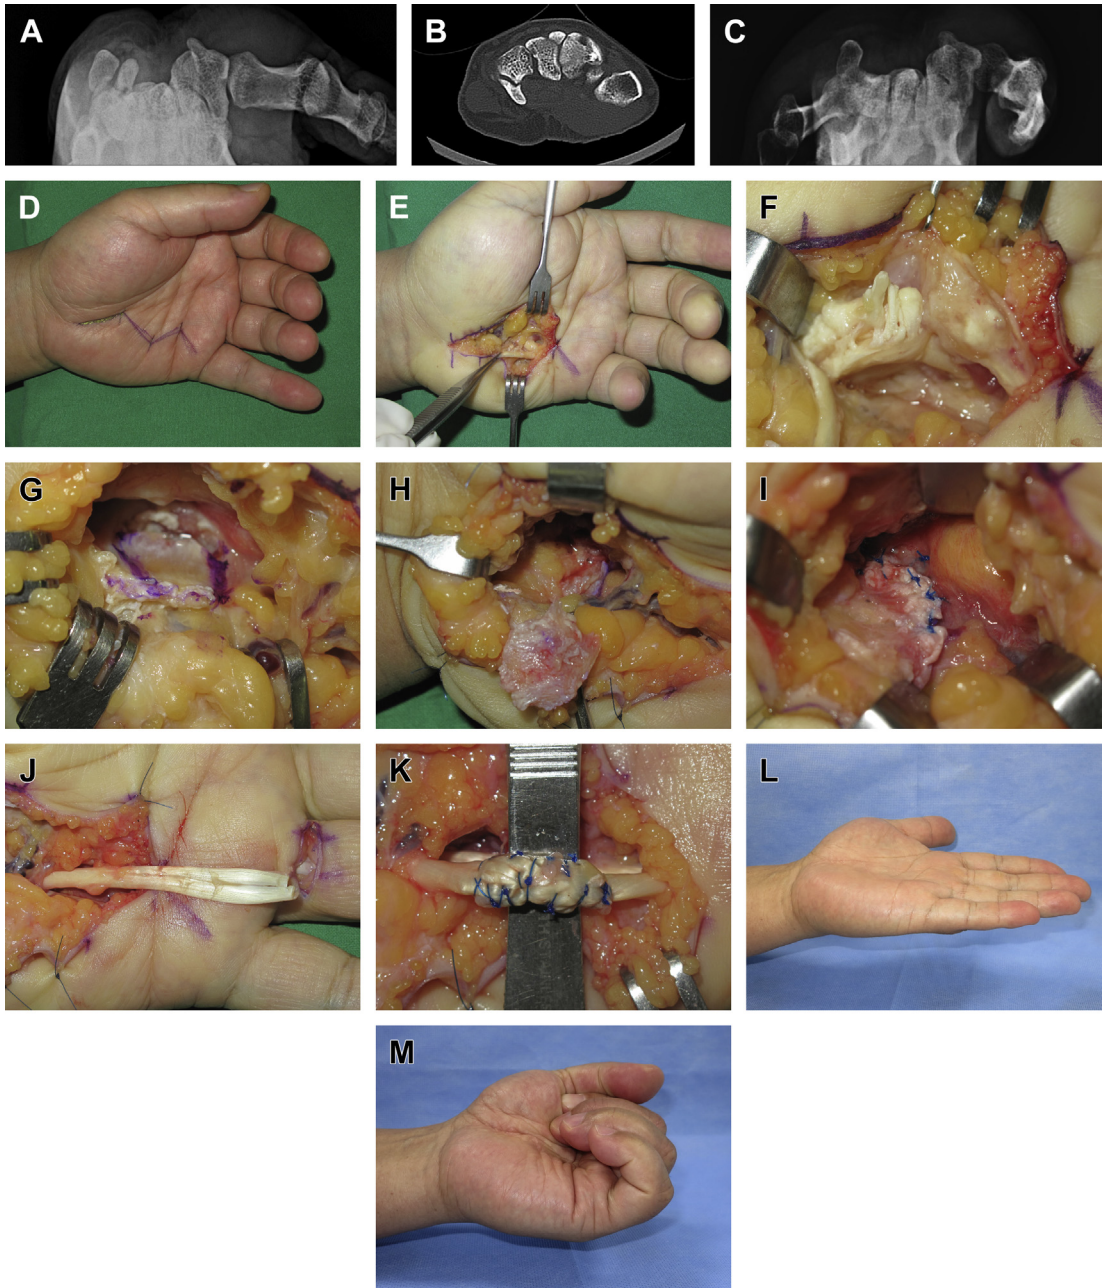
Beginner golfer: a 56-year-old male patient had chronic pain on the left palm and limitation of flexion on the ring and small fingers after intensive golf practice for 3 months. (A, B) On the radiograph of the carpal tunnel view and computed tomography, the base portion of the hook of hamate was fractured. (C) Postoperative carpal tunnel view after resection of the fracture segment. (D) The preoperative view showed destroyed cascade of the ring and small finger and preoperative design for resection of the fractured segment of the hook of hamate, and fourth flexor digitorum superficialis (FDS) tendon transfer for the reconstruction of the fifth flexor digitorum profundus (FDP) together. (E) Complete ruptured fifth FDP at zone III. (F) The fourth FDP was also longitudinally torn. (G) Fractured hook of hamate was identified and periosteal flap based from the ulnar wall of carpal tunnel was designed with gentian violet. (H, I) The fracture segment was excised and then the raw surface was resurfaced with periosteal flap. (J, K) The fourth FDS was harvested from the small transverse incision on the metacarpophalangeal volar crease. Pulvertaft interweaving suture was performed between the proximal end of the fifth FDP and distal end of the fourth FDS. (L, M) 36 months postoperation.
